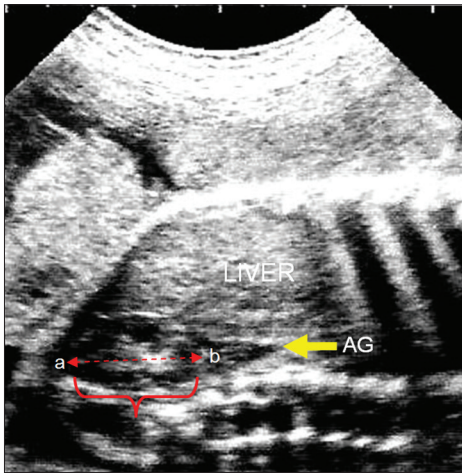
Coned longitudinal sonogram of the fetal right kidney with the fetus in supine position. The kidney is seen as an elliptical structure with a central echogenic sinus and hypoechoic cortex. The broken red arrow shows the measurement of the kidney length from superior outer pole to inferior outer pole, between points a and b. The yellow arrow points to the fetal adrenal gland, seen as an inverted V-shaped hypoechoic structure located adjacent to the superior pole of the kidney
